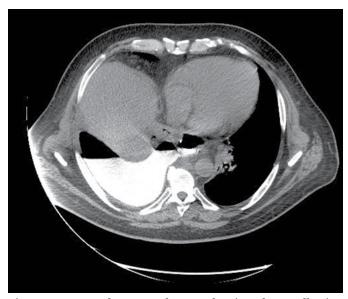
Computed tomography scan showing a large collection of oral water-soluble contrast medium (gastrografin) at the esophagogastric anastomosis spreading in the right pleural cavity.
